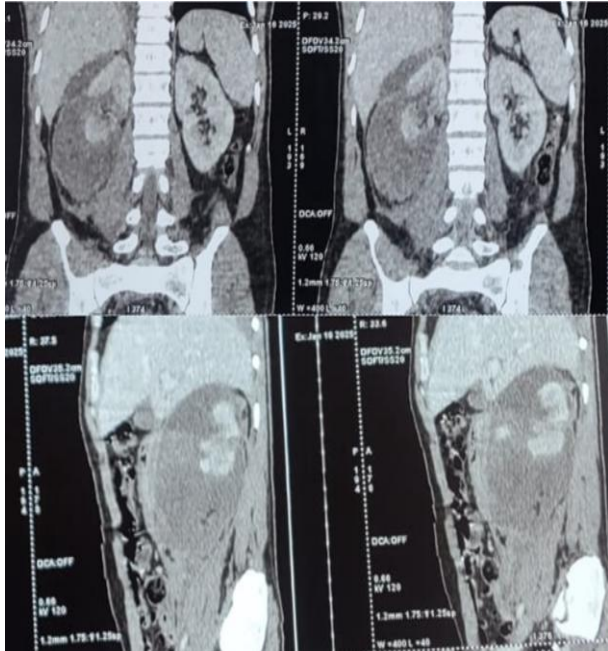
Contrast-enhanced CT images of a renal trauma (AAST grade IV).
